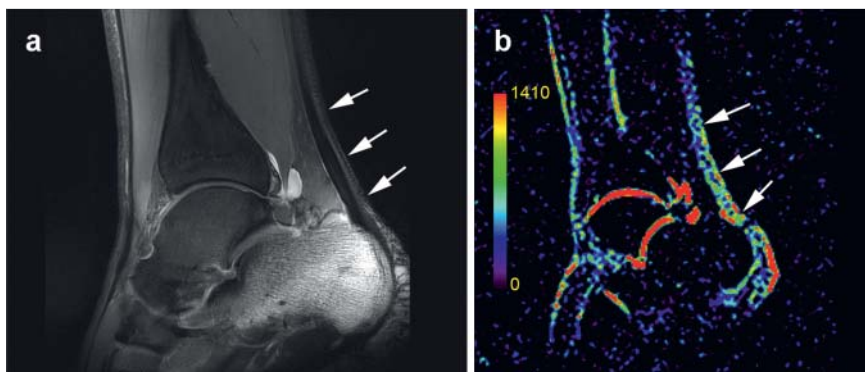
shows a conventional sagittal 1H MR image a in comparison to ^{23}Na imaging b in a 39-year-old patient with insertional tendinopathy at 7 T. A diffuse sodium distribution is present within the Achilles tendon, which is marked by white arrows (courtesy of Prof. Trattng and co-workers, Vienna, Austria).
